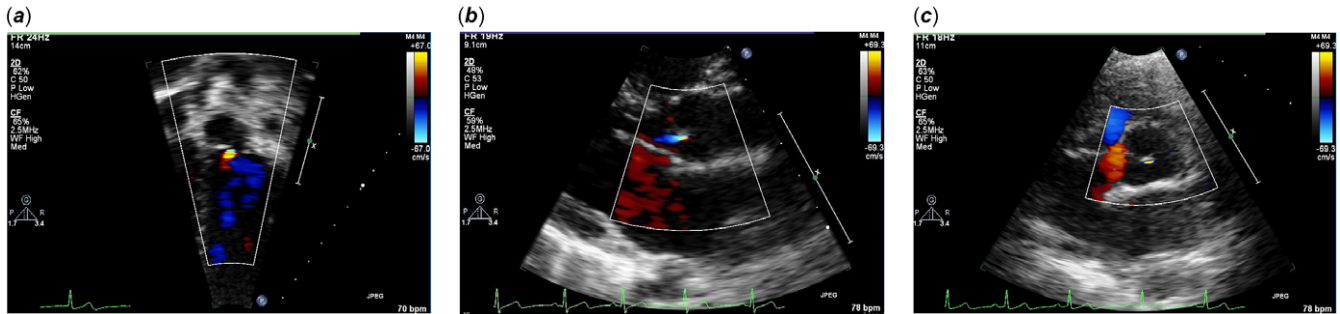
Trivial aortic regurgitation in (a) Apical 5-chamber view, (b) Parasternal long-axis view, and (c) Parasternal short-axis view.
